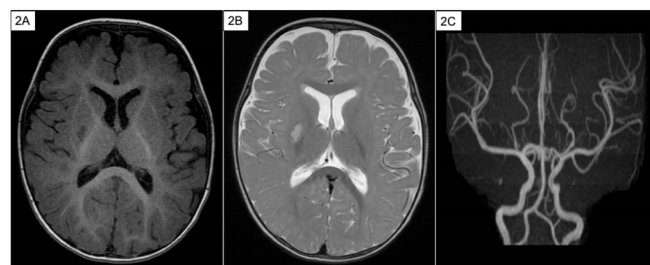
Representative axial T1-weighted (2A) image showing hypointense signal in the right globus pallidus and putamen region. The corresponding T2-weighted (2B) MRI image shows hyperintense signal in the same region as 2A. Magnetic resonance angiography (2C) demonstrates no evidence of flow-limiting stenosis. Of interest, these MRI images are incongruent with the previously described MRI findings of mineralizing microangiopathy [24]. However, these findings are also consistent with the negative MRI results seen in lenticulostriate mineralization—the subtype of mineralizing microangiopathy associated with acute basal ganglia stroke in infants presenting after minor head injury [17].
